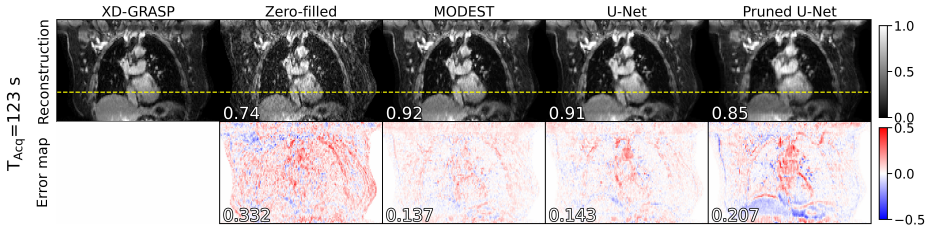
Example free-breathing undersampled reconstructions. 4D-MRI was acquired of a female, 71 years old, affected by squamous cell carcinoma (T2N1M0). Reconstructed 4D-MRI by MODEST, a U-Net, and the parameter-pruned U-Net are shown using an acquisition of 500 spokes (approx. 2 minutes) and are compared to the target XD-GRASP reconstruction. The top row shows the magnitude reconstructions and the SSIM, while the bottom row shows the NRMSE map and the mean NRMSE value for the 4D reconstruction.
